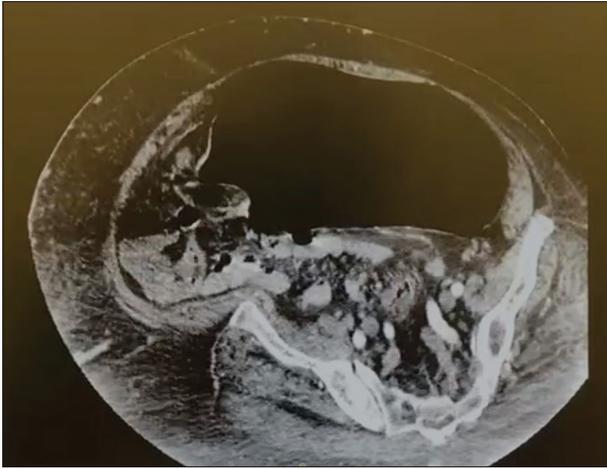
CT abdomen showing a massively dilated sigmoid colon with evidence of volvulus (red circle) in the context of chronic intestinal pseudo-obstruction
